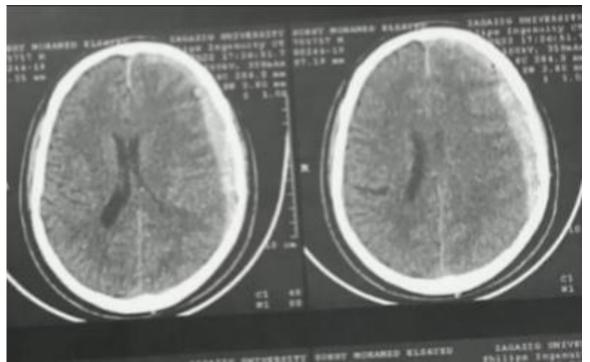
CT scan showing a large amount of acute subdural hematoma with midline shift <sup>(7)</sup>.
